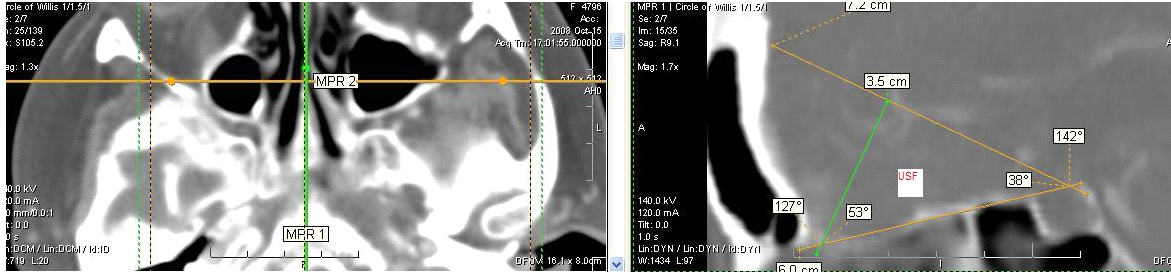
CT exploration with 3D reconstruction, USF=38°
